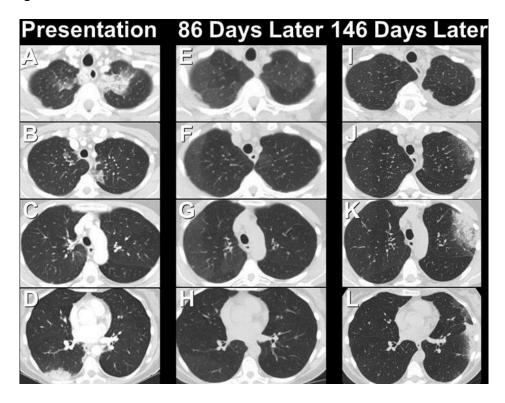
Comparison of the presentation chest CT (A-D), follow up chest CTs performed 86 (E-F) and 146 (I-L) following presentation shown at selected levels shows the transient and migratory areas of non-segmental peripheral and frankly subpleural areas of ground-glass opacity and consolidation.
